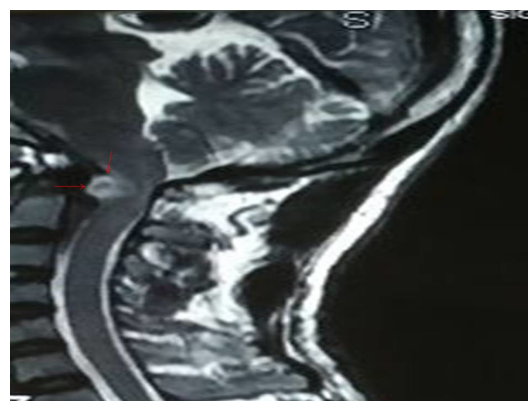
MRI T2-weighted sagittal sequence showing 'dumbbell shaped' lesion (red arrow) compressing the upper cervical cord (yellow arrow) at the craniovertebral junction.
